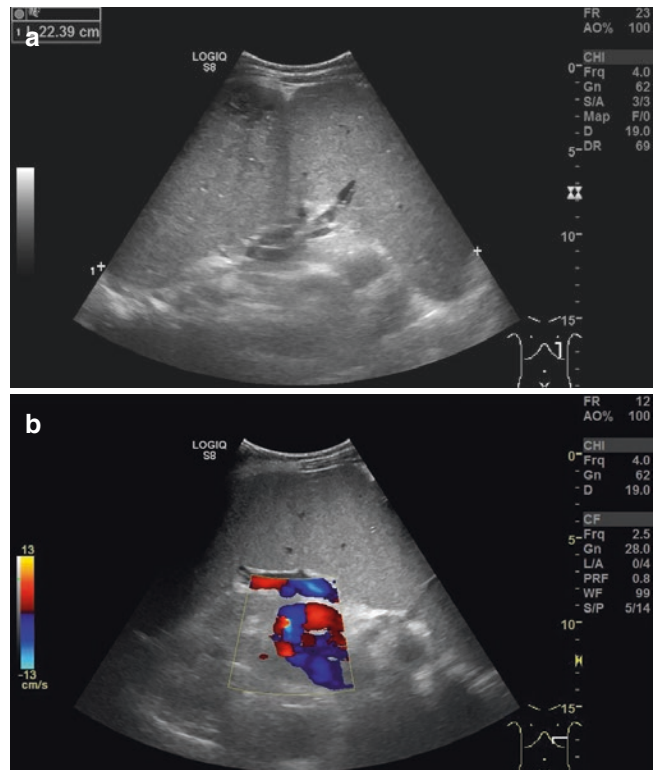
(a) Ultrasound axial sections of the liver reveals irregular nodular surface of the liver with coarse echogenicity of the liver parenchyma. Ultrasound coronal section of the spleen (b) reveals splenomegaly with varices at the hilum
